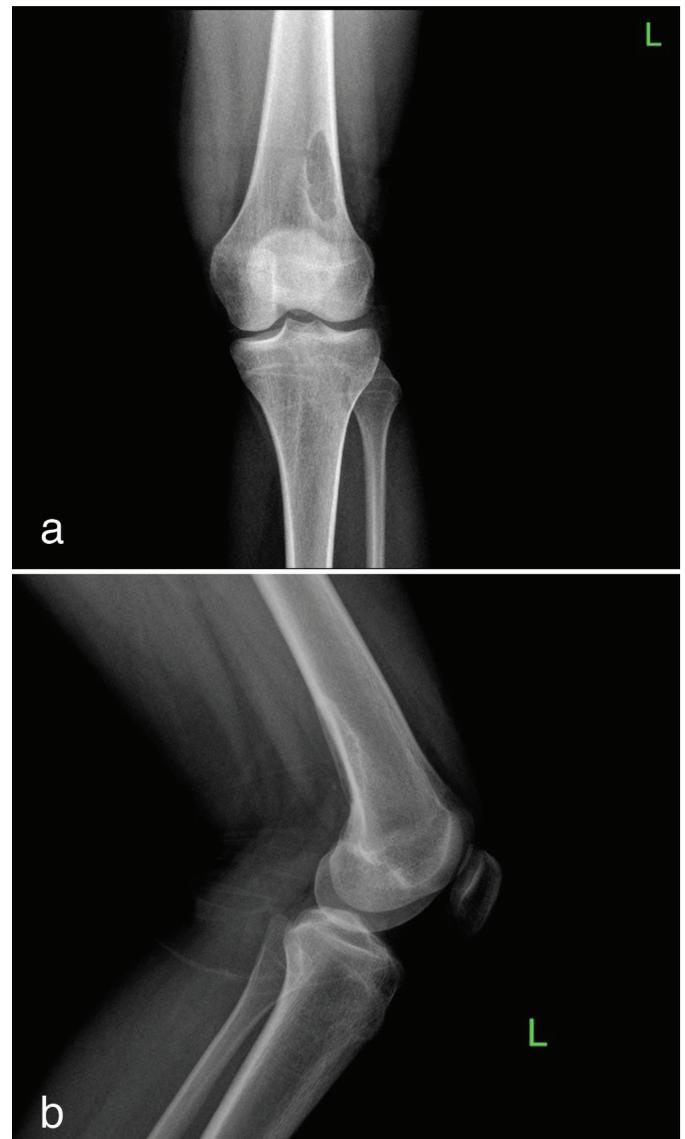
Knee radiographs of a 15-year-old patient's non-ossifying fibroma of the distal part of the femur (stage A)
